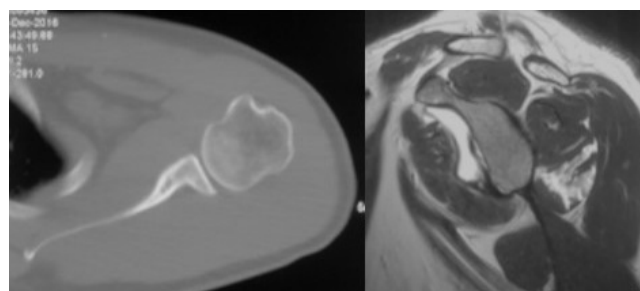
Preoperative computed tomography (axial view) and magnetic resonance arthrography (sagittal view)
